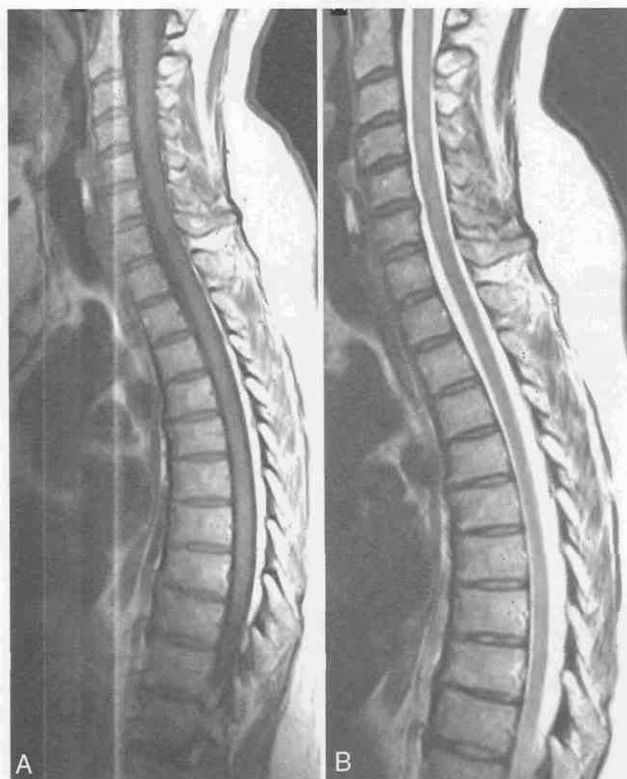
Sagittal fast spin-echo, T1-weighted (A) and T2-weighted (B) thoracic MR images. The entire thoracic spine as well as the cervical spine is easily included in the field of view.
